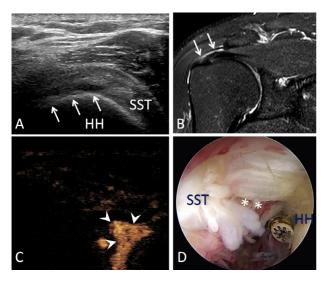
Articular-side partial-thickness tear in a 35-y-old man. (A) Ultrasound image revealed a hypo-echoic area with unclear bursal-side margin on the articular side of the tendon (↑↑↑), which was shown on ultrasound (US) imaging in a long-axis view. There seemed to be a small articular-side partial-thickness tear with about 30% of the cuff thickness involved. (B) Oblique coronal T2-weighted image revealed a brighter signal on the bursal side of the involved tendon (↑↑). (C) Percutaneous ultrasound-guided tendon lesionography image revealed contrast agent filling in the tear area of the articular side more clearly, and leaking into the glenohumeral joint cavity in real time (arrowhead), which indicated a large articular-side partial-thickness tear in the long-axis view. (D) Arthroscopy confirmed a large articular-side partial-thickness tear (). HH = humeral head; SST = supraspinatus tendon.
